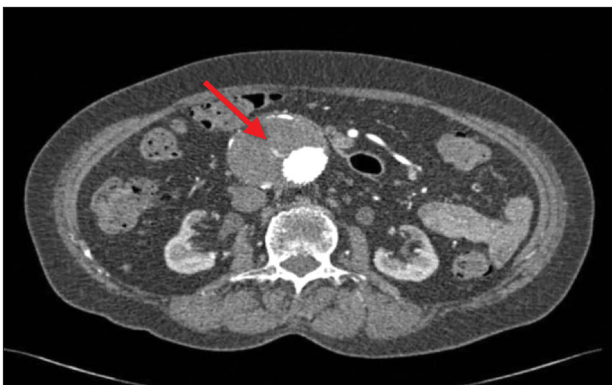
Follow-up computed tomography after endovascular aneurysm repair showed the increase of aneurysmal sac from 6.2 cm to 6.95 cm, and type 2 endoleak was present. A type 3 endoleak (arrow) was suspected in this single transaxial image.
